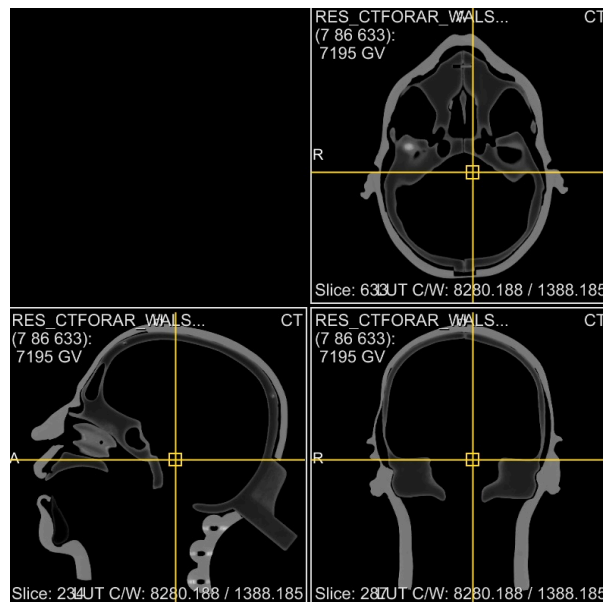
Dicom CT slices of head model
